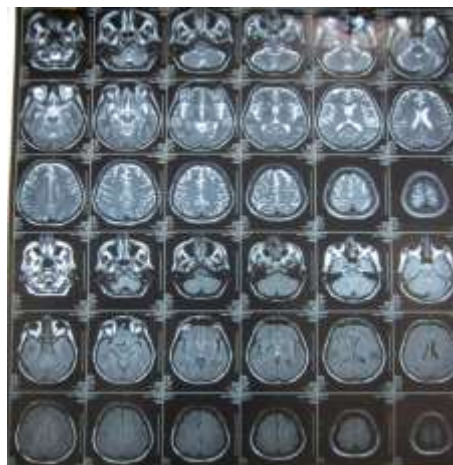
Patient brain MRI
